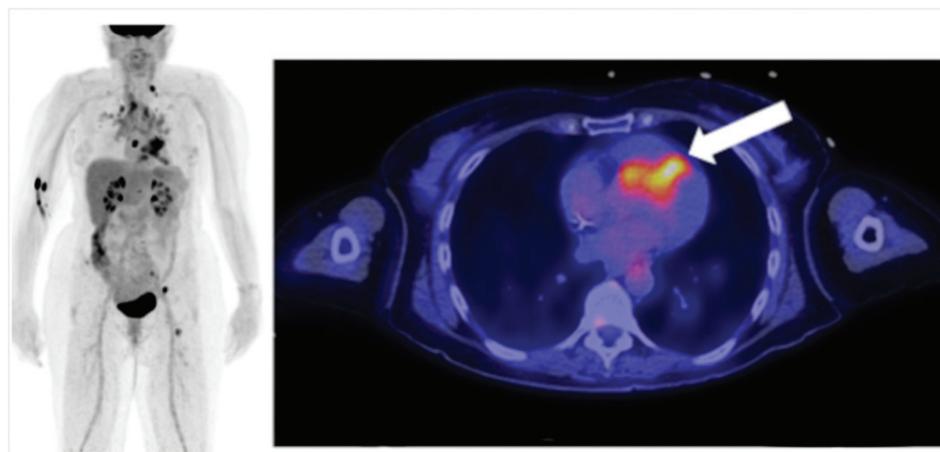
An example of FDG PET in a patient with cardiac sarcoidosis. In addition to being able to detect myocardial inflammation, whole body FDG-PET can detect extra-cardiac sites of involvement and provide a better picture of the disease stage.
